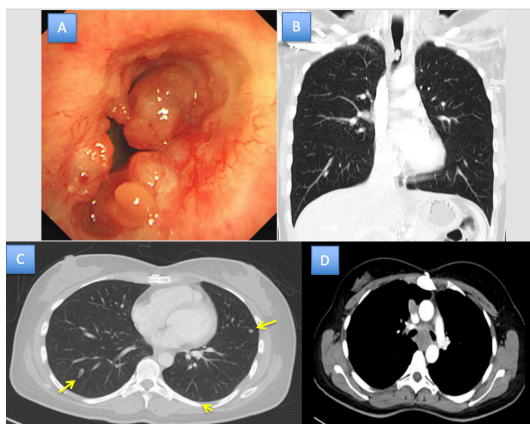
(A) Malignant polypoidal tracheal tumour with 80% obstruction (B) CT coronal view showed polypoidal lesion in mid-trachea (C,D): CT surveillance showed enlarged subcarinal lymph node and multiple pulmonary nodules (yellow arrows).
